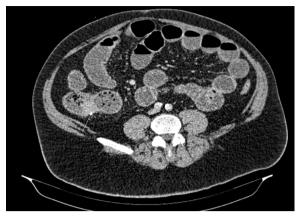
Axial computed tomography image post intravenous contrast media administration showing a hyperdense soft tissue mass (white arrow) at the region of the ileocecum valve as the cause of the ileocecal intussusception.
